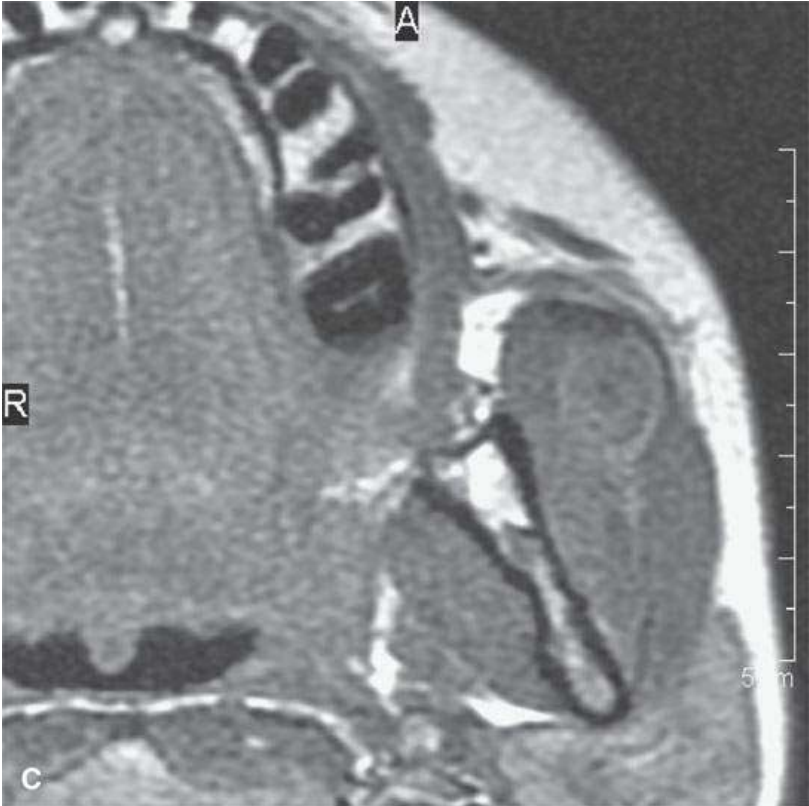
Penetrating plant material mimics a calcified foreign body on the computed tomography in (A). It is not really visible (*arrow*) on the fat-suppressed T1-weighted magnetic resonance imaging in (B), but it can be seen (*arrow*) as a void on the coronal T2-weighted image in (C).
